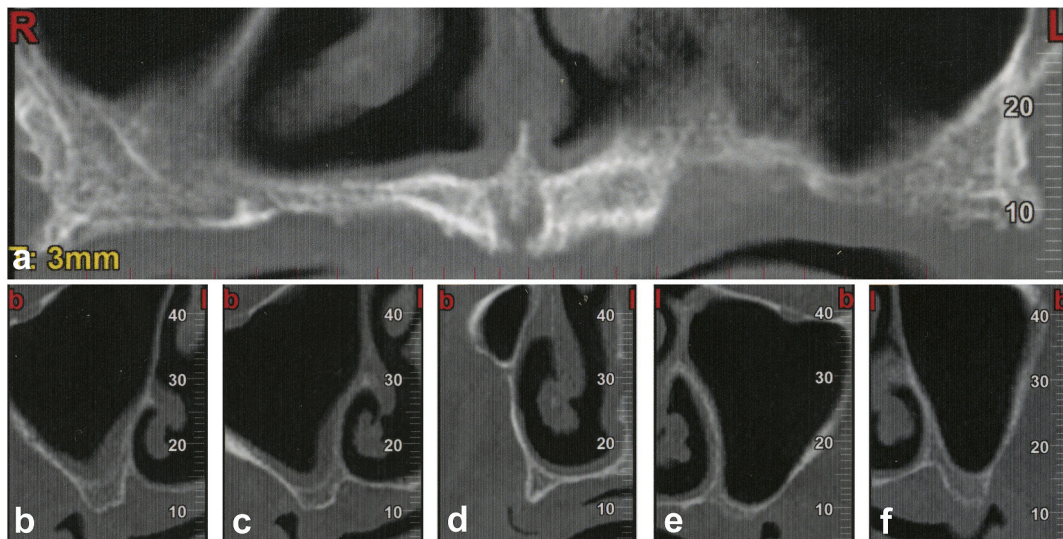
(a–f): Baseline Cone Beam Computed Tomography (CBCT) scans showing a fully edentulous maxilla with different degrees of extreme bone atrophy.
